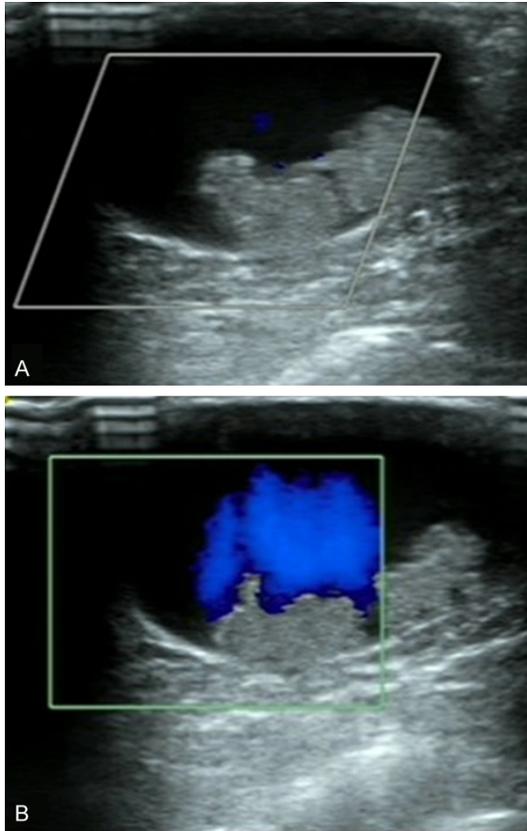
A and B. Ultrasound scan shows an obvious papillary lesion.
